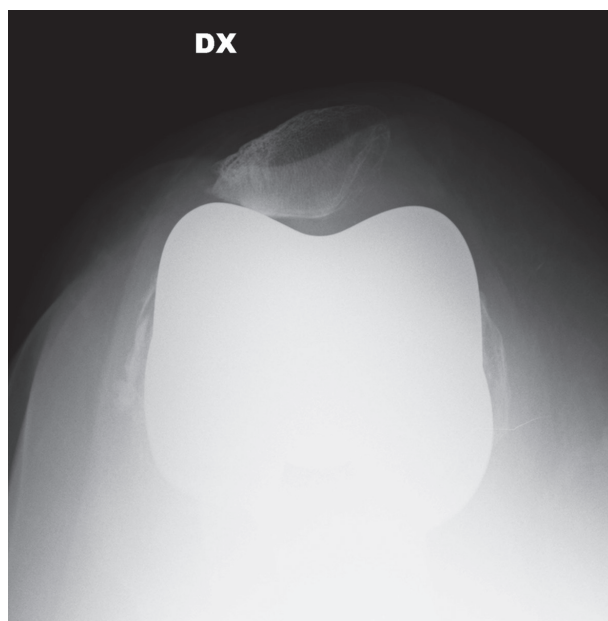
X-rays axial view shows TKA with patellar maltracking
